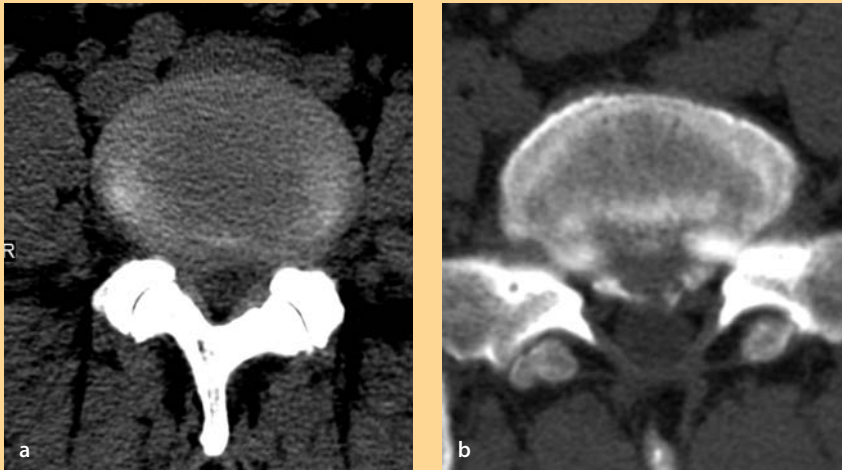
CT diagnosis of disc herniation
